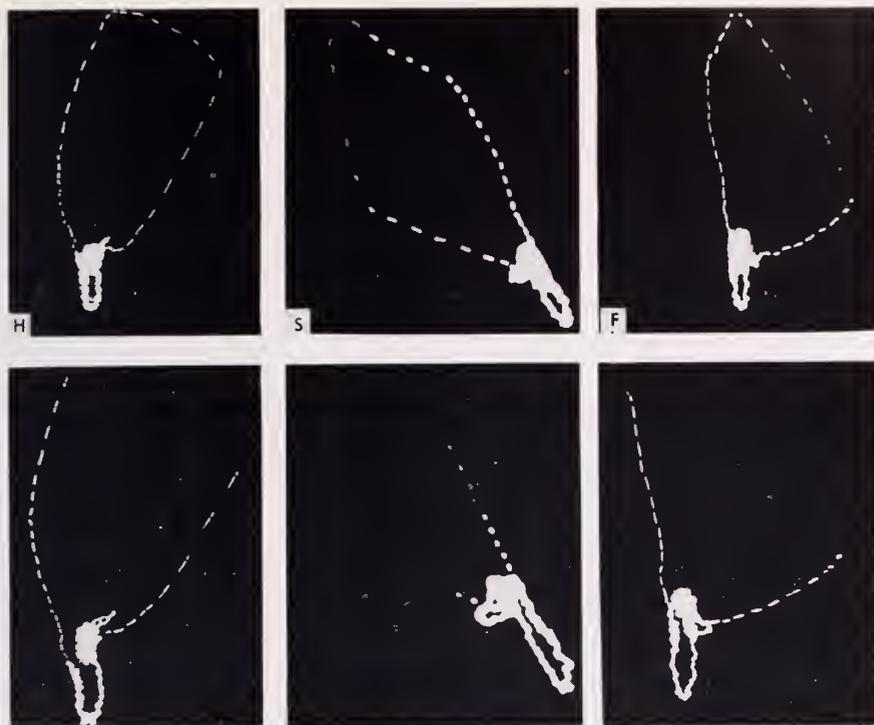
I. B., 76 year-old male. Essentially asymptomatic arterial hypertension of 240/110 mm Hg. Radiographic examination of the chest showed no cardiac enlargement and only moderate elongation and tortuosity of the aorta. The VCG is oriented superiorly, to the left and posteriorly, with slowed rate of inscription of its terminal segment. The QRS loop turns initially to the left and slightly inferiorly. The ST vector is oriented to the right and anteriorly associated with a discordant T loop.
